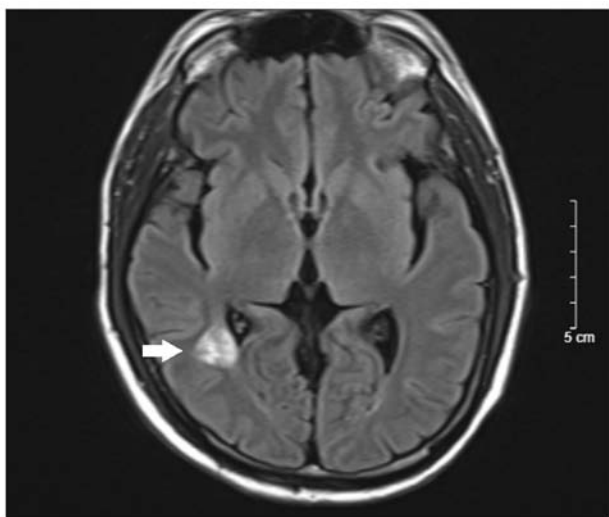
Cranial magnetic resonance image in September 2022 reveals that the lesion (white arrow) had decreased in size.
